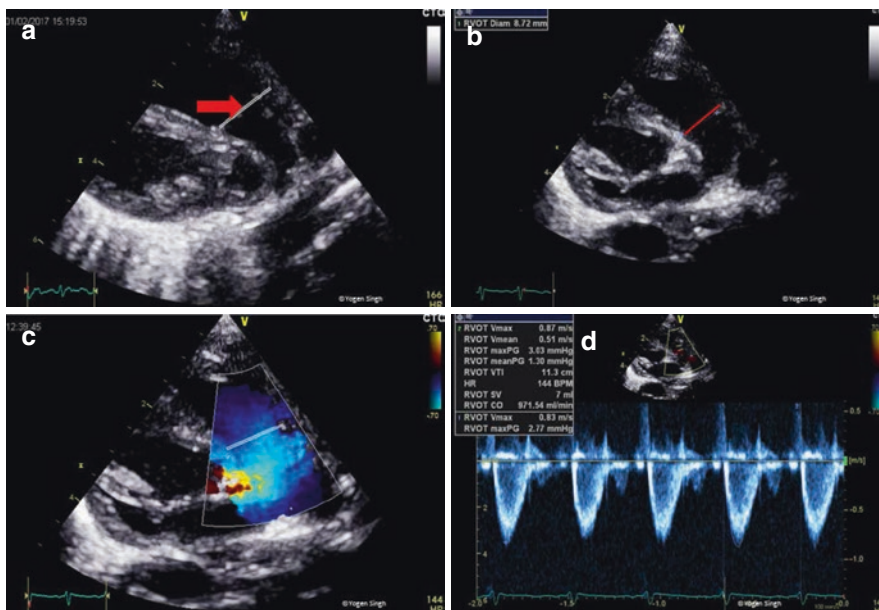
Assessment of right ventricular output (RVO) on echocardiography. (a) RV outflow tract (red arrow) and (b) measurement of PV annulus (red line) at the hinge point of AV valve. (c) RV outflow tract and the site for PW Doppler to measure VTI (red line showing PW sample
